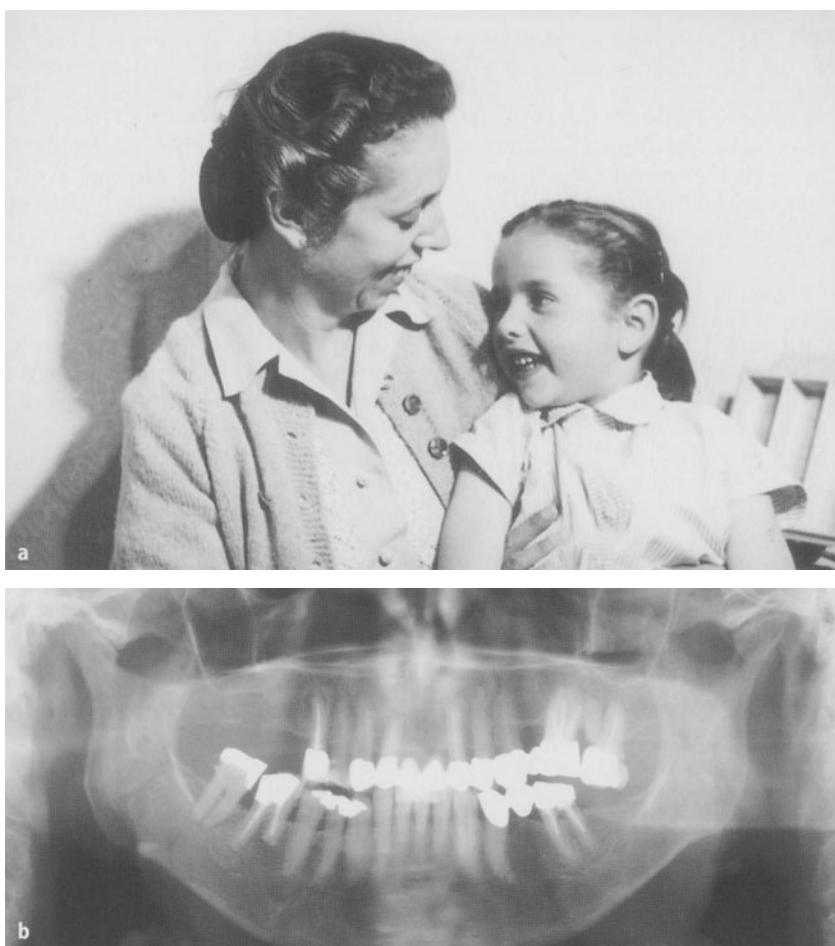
Bilateral condylar hypoactivity due to arthritis in early childhood in a case of anlage-induced micromandibulism. a The patient at the age of 4 years has a normal chin configuration and a normal position of the mandible, while her mother has a typical appearance of micro- and retromandibulism with retrogenia. b Mother's panoramic radiograph taken at age 78 shows the same type of mandible as seen in Fig. 11d and also no condylar hypoplasia
